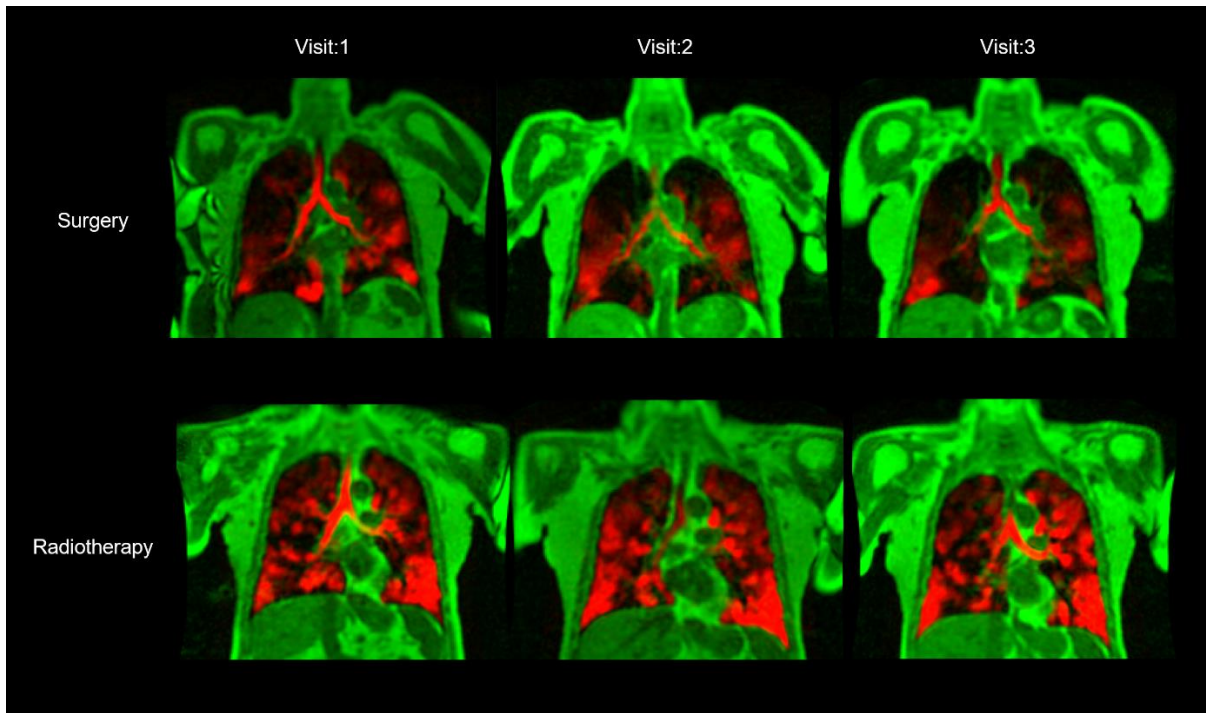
Hyperpolarised  $^{129}\text{Xe}$  gas ventilation MRI (red) overlaid on anatomical proton MRI in two NSCLC patients who underwent surgery (top) and radiotherapy (bottom) over three visits.
